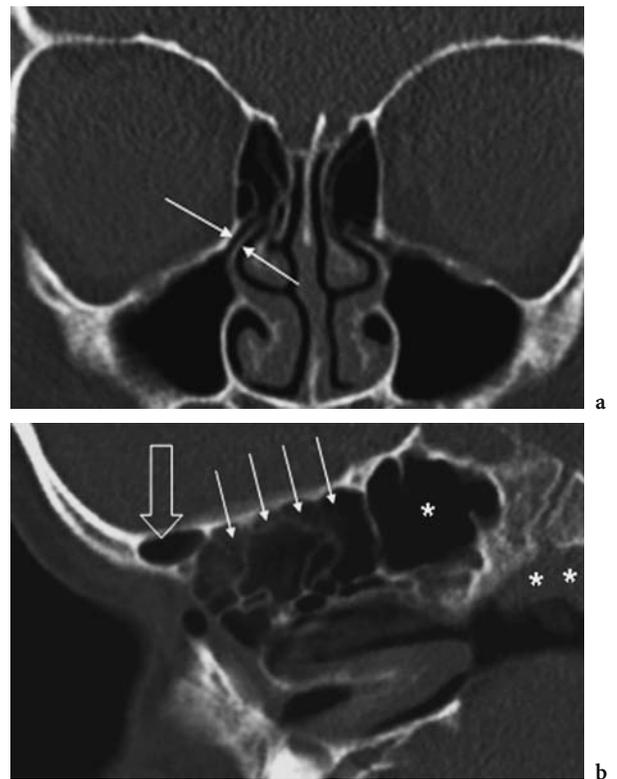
Normal findings in low-dose CT exam of the sinuses in a 6-year-old girl (6-MDCT, $CTDI_{vol}$ of 1.68 mGy, effective dose of 0.035 mSv). a Coronal 2 mm image shows normal maxillary and ethmoidal sinuses with clear depiction of infundibulum, medially bordered by the uncinete process (arrows). b Sagittal 2 mm image shows normal frontal sinus (open arrow), ethmoidal cells (small arrows), sphenoid sinus (asterisk) and adenoids (double asterisks)
